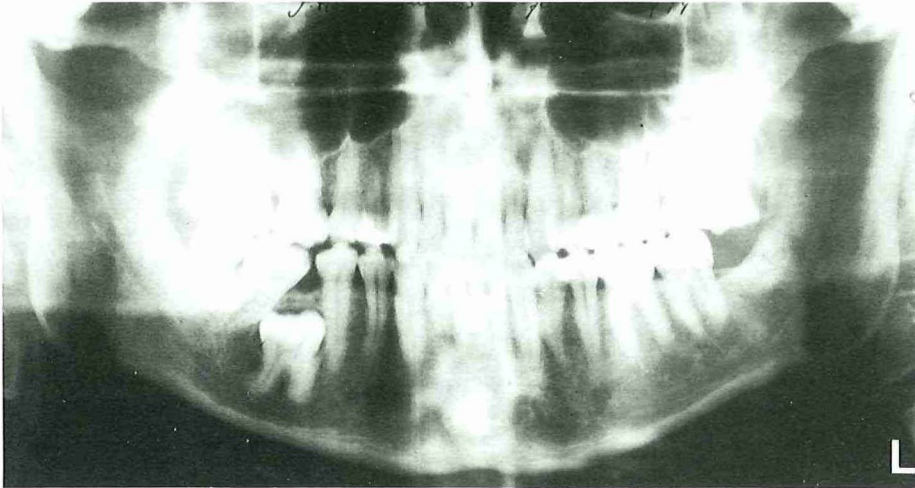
Orthopantomogram of a 32-year-old male showing primary retention of the mandibular right first molar. The crown is covered by bone.
